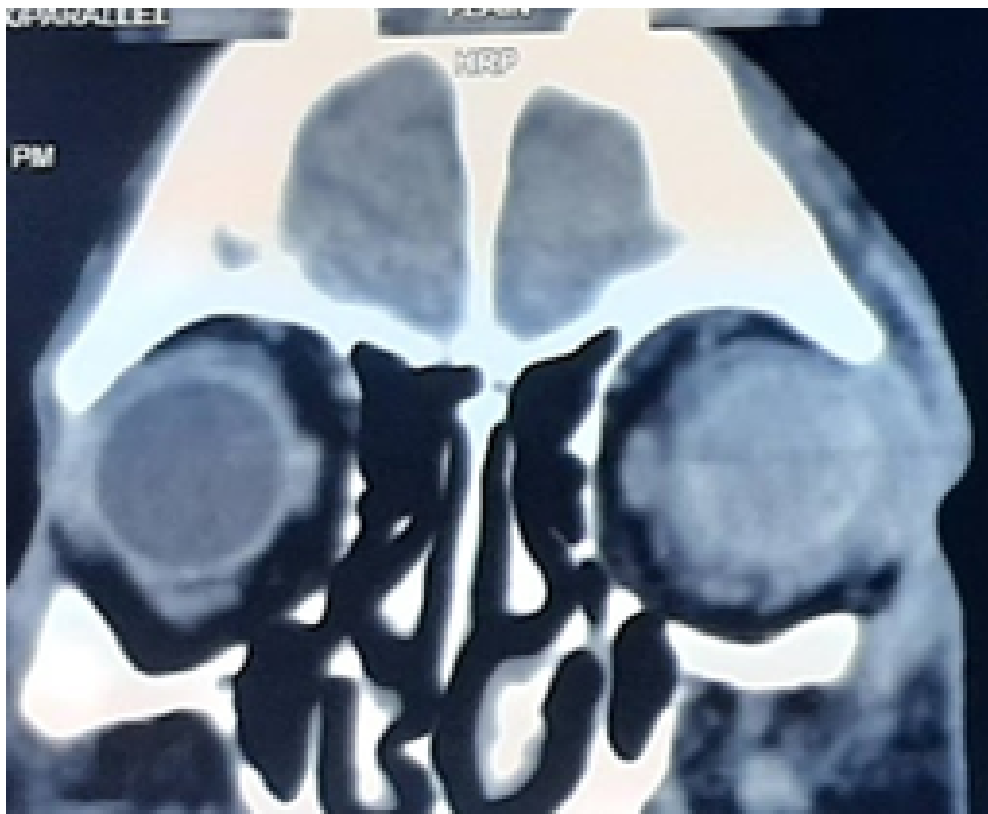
A CT scan of the eye shows thickened sclera and intraocular contents, indicating panophthalmitis.
